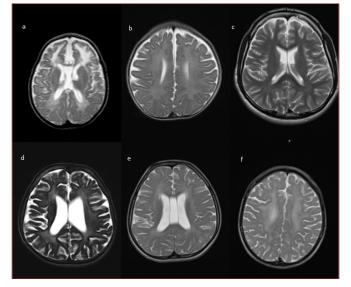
Axial T2 non-contrast brain MRI images T2A hyperintense hypomyelinated areas in periventricular white matter *MRI: Magnetic resonance imaging*
